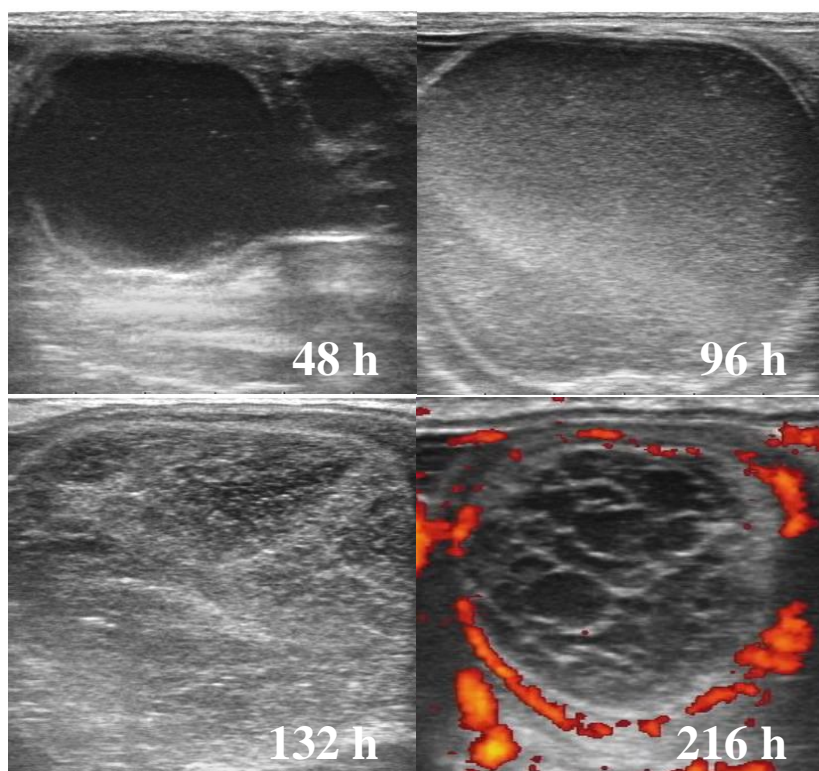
B-Mode and colour-Doppler (216 h) sonograms of a mare from LUF-control group. The mare was administered 1.7 mg/kg flunixin-meglumine i.v. every 12 h 0 to 36 h after hCG treatment (0 h). Note the high degree of follicular haemorrhage at 96 h. By 132 h the follicular contents had organized and did not move upon ballottement of the ovary. At 216 h after hCG (day 9) the LUF wall is highly vascularised indicated by colour-Doppler signals around most of the wall circumference of the LUF. The peripheral progesterone concentration at 216 h was 3.96 ng/ml.
